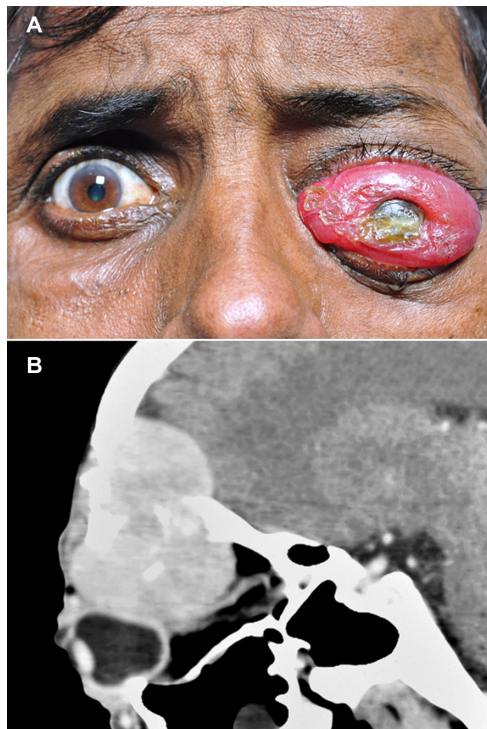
External photograph and CT scan of the patient showing gross proptosis of the left eye with severe conjunctival chemosis, and a large mass lesion in the superior orbit. External photograph of the patient showing gross proptosis of the left eye with severe conjunctival chemosis (A). CT scan with sagittal reconstruction showing a large mass lesion in the superior orbit with extension into the frontal sinus and intracranial space (B).
